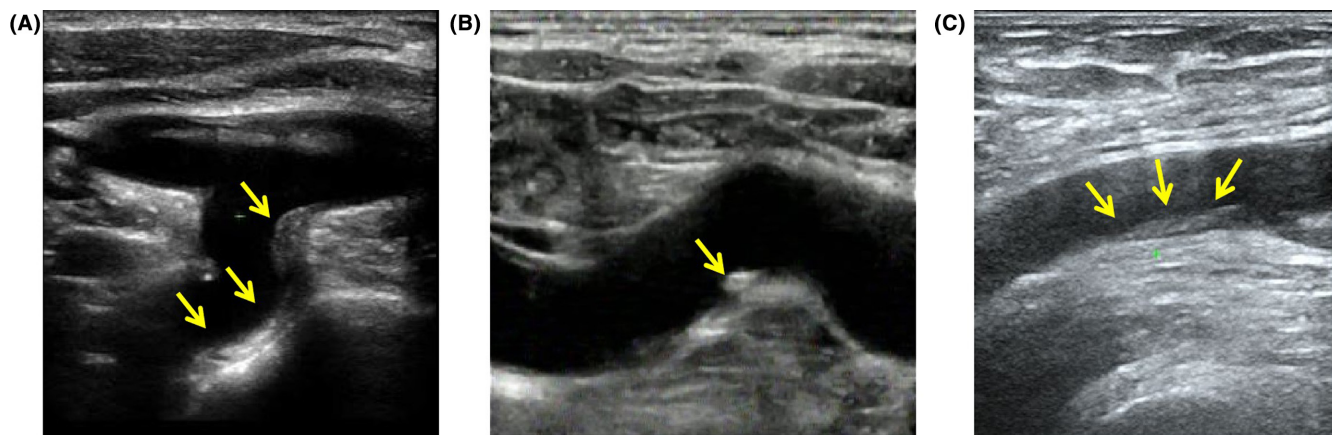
Ultrasound of arterial vessels reveals diabetic peripheral vascular disease in the three patients. Atherosclerotic plaques are indicated by arrows (A) for Case 1, (B) for Case 2, and (C) for Case 3.
